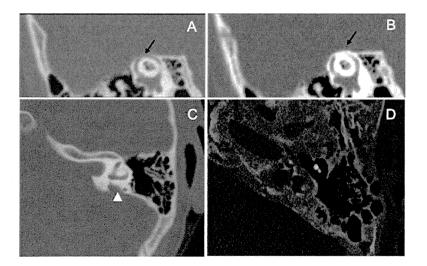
CT findings of a 30 year-old male with superior semicircular canal dehiscence before (A) and after (B) re-pair of the roof with bone cement. C: Enlarged vestibular aqueducts in a 15 year-old male, D: Paget's disease in 70 year-old male. The arrows show the roof of the superior semicircular canal (A, B) and the arrow head shows the en-larged vestibular aqueduct (C).
